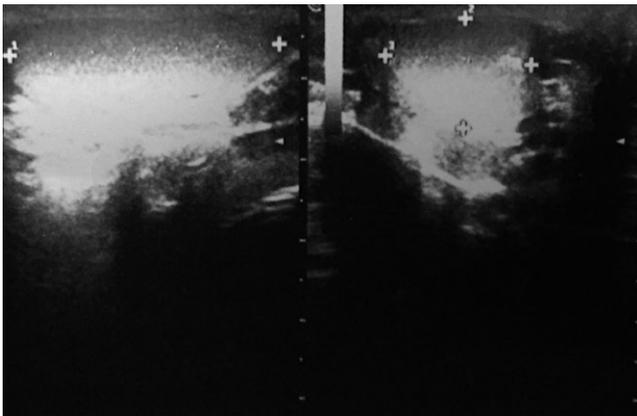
Scrotal ultrasound image of left testis
